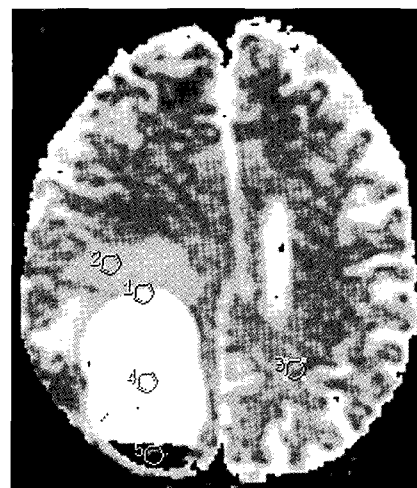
ADC mapping image obtained from the software of the magnetic resonance image system. Each small circles represent the region of interesting (ROI) and apparent diffusion coefficient (ADC) values were calculated directly from the software. Number 4 indicates the center of the lesion and number 3 indicates the opposite site of lesion.
